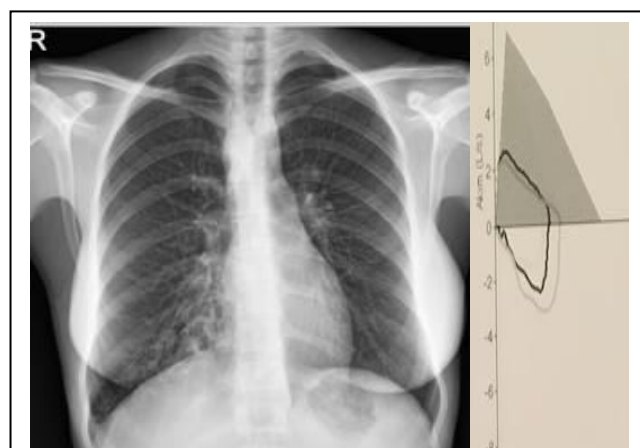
Chest radiography of 23 years-old female showing the right sided arcus aorta and flow-volume curves showing the quadrilateral lateralization pattern on spirometry.
